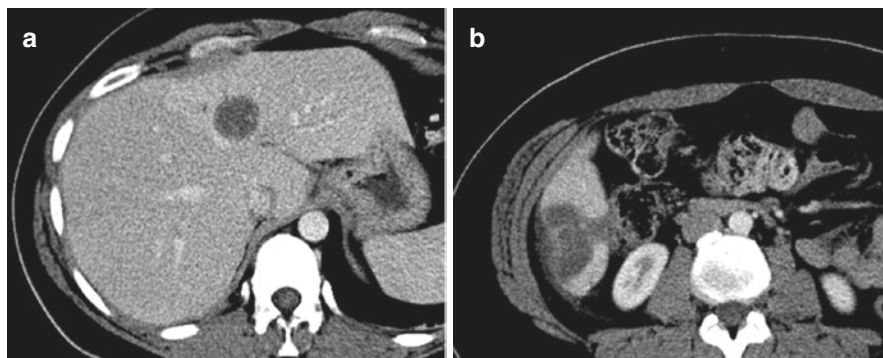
Epithelioid hemangioendothelioma. Single-phase CT images from a 31-year-old woman with biopsy-proven hepatic epithelioid hemangioendothelioma. Multiple hypoenhancing hepatic lesions are seen in the anterior left lobe (a) and the inferior right lobe (b). Note the presence of capsular retraction adjacent to both lesions. Alternative etiologies with similar single-phase imaging features would be expected to result in capsular bulge
